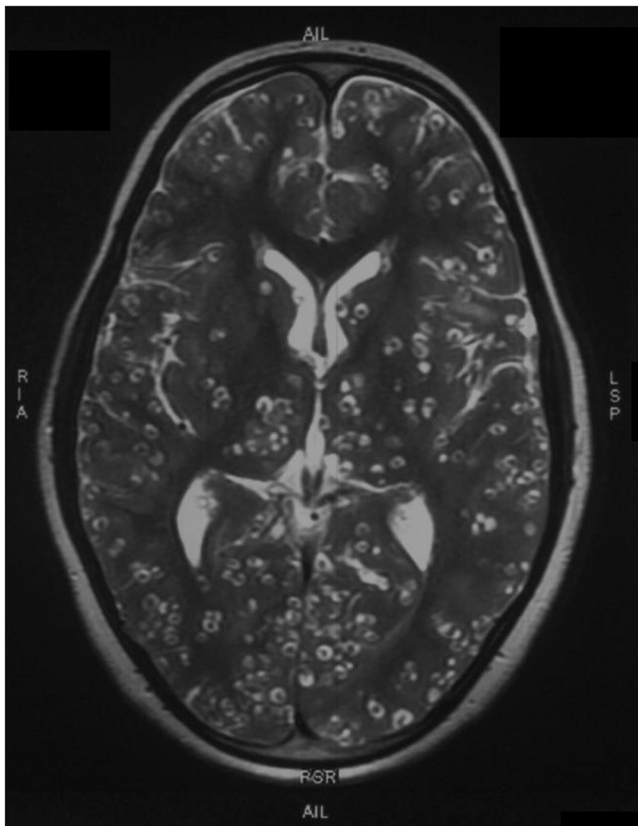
Axial T2-weighted MRI showing multiple hyperintense cystic lesions with eccentric dot-like foci ("scolex") visible throughout the brain parenchyma, consistent with neurocysticercosis in the vesicular stage. These lesions are diffusely distributed, involving the cortex and deep structures, demonstrating the classic imaging appearance of neurocysticercosis.
